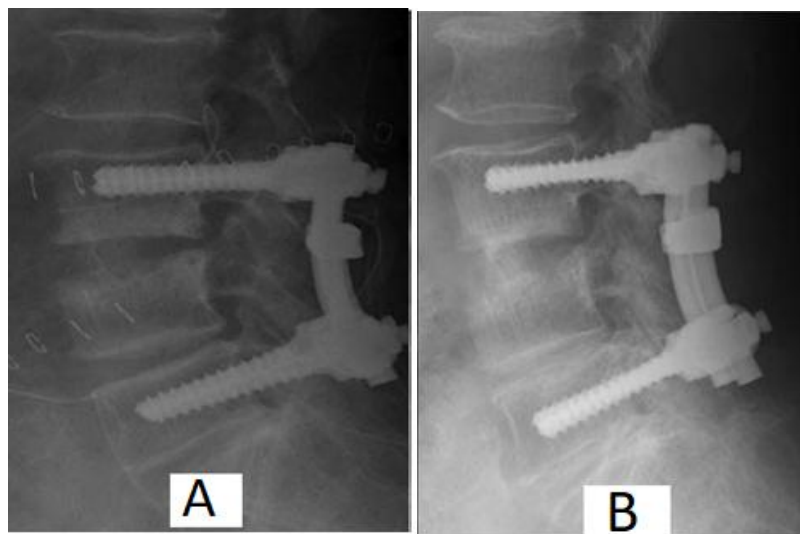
A Immediate postoperative x-ray, B: Follow up X-ray after 3 months. Showing pedicle screws fixation with correction of kyphosis. VAS score = 4. Frankle scale was improved from C to D.
